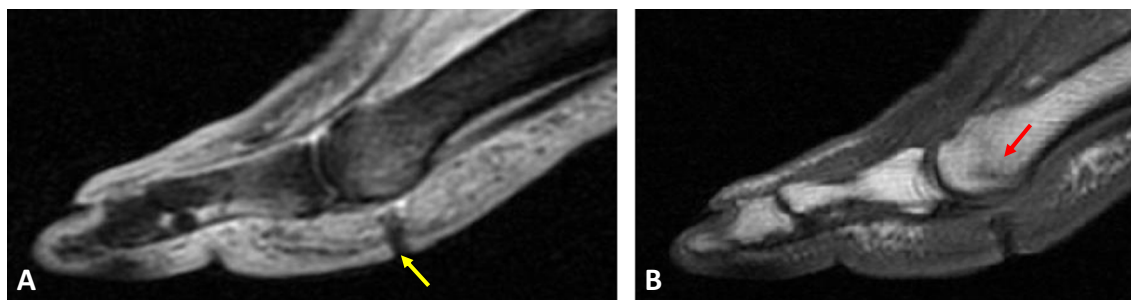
A 58-year-old man with an ulcer (yellow arrow) subjacent to the great toe MTP, demonstrating the hazy reticular pattern of T1 signal change, which is not associated with osteomyelitis. There is mild bone marrow edema of the head of the first metatarsal evident on the sagittal STIR image (a). The corresponding T1-weighted image (b) demonstrates hazy reticular decreased signal (red arrow), with intervening fat present
